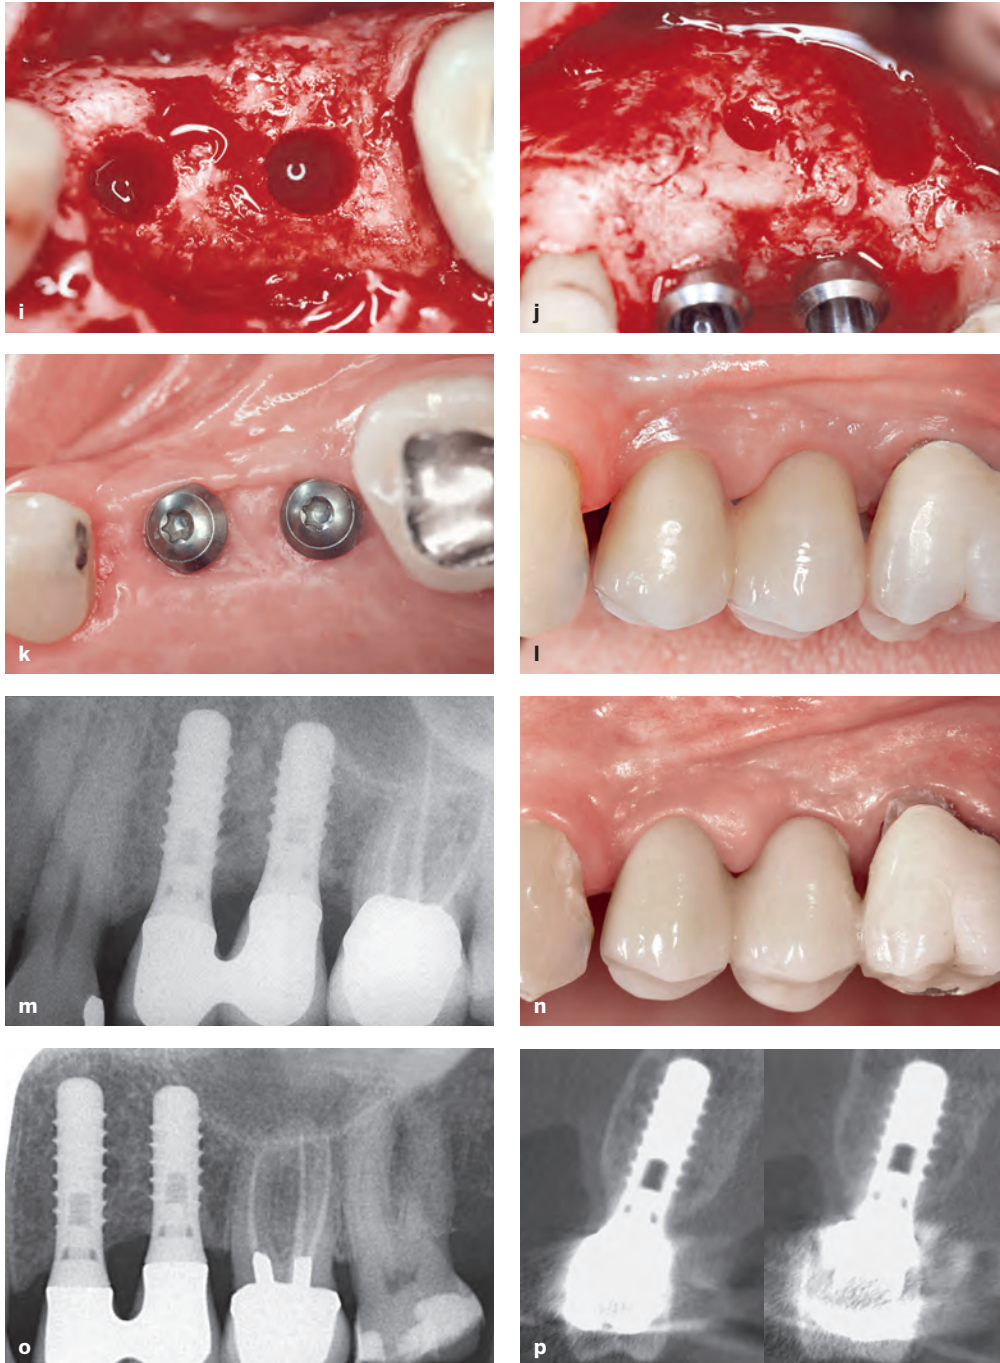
Case 2. (cont) (i) Following flap elevation and membrane removal, the occlusal view demonstrates an excellent ridge volume and thick buccal bone wall following implant bed preparation. (j) The buccal view confirms successful ridge augmentation. The block graft can still be recognized, and it is covered in some areas with newly formed bone. (k) Clinical status following 3 months of nonsubmerged healing for both implants. The peri-implant mucosa was healthy and included a nice band of keratinized mucosa. (l) Clinical status at the 10-year examination (2005) shows the two splinted implant crowns. The peri-implant mucosa was stable with no signs of a peri-implant pathology. (m) The periapical radiograph at the 10-year examination confirms stable bone crest levels around the two tissue-level implants with a hybrid design. (n) The 25-year follow-up examination (2019) shows the clinical status with quite healthy peri-implant mucosa, although the plaque control is no longer perfect in this elderly patient (age 86). (o) The periapical radiograph confirms stable bone crest levels at both tissue-level implants. (p) The CBCT scan shows fully intact, thick buccal bone walls for the implants in the first premolar (left) and second premolar (right) sites.
